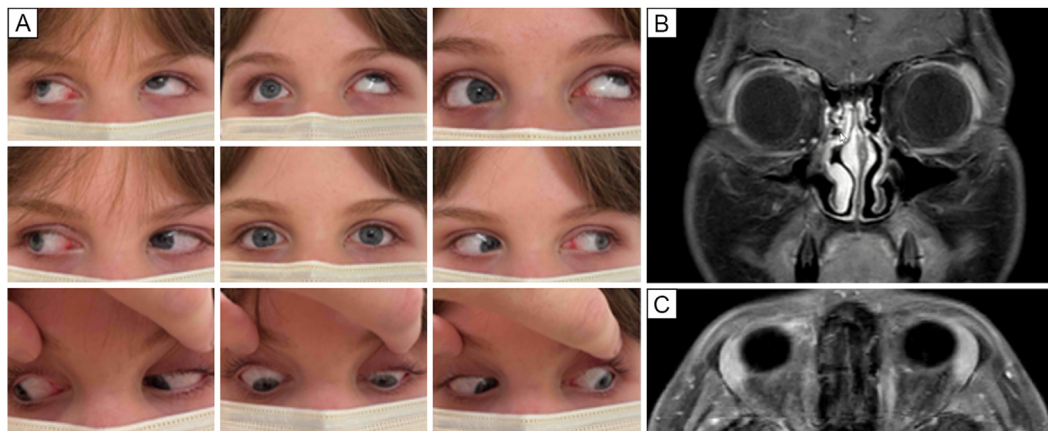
A, Sensorimotor examination showing limitation of adduction in elevation of the right eye, 3 weeks after COVID-19 diagnosis. B-C, Magnetic resonance imaging of the intracranial space and orbit on the day of presentation. Focal enhancement of the right trochlea is noted on post-contrast T1-weighted coronal (B) and axial (C) images (arrows) without involvement of the right superior oblique muscle or right orbit.
